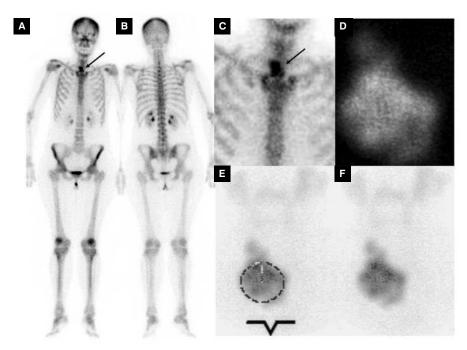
This figure shows anterior view (A), posterior view (B), and anterior magnified view (C) of Tc-99m methylene diphosphonate (MDP) scintigraphy revealing abnormal extraosseous uptake (black arrow). Tc-99m-pertecnethate thyroid scintigraphy is also reported in white background with (E) and without (F) jugular landmark and in black background (D).
